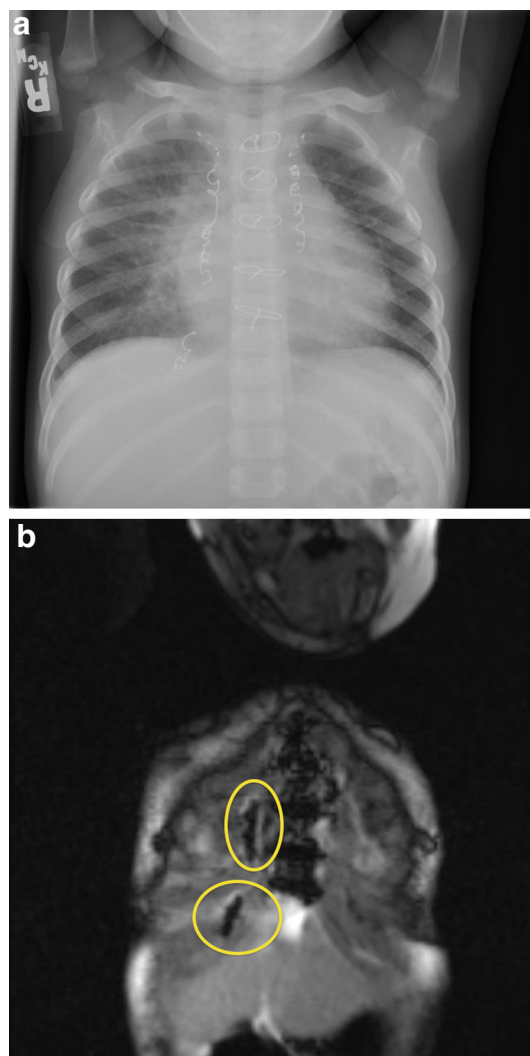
Examples of Inconel coils by chest radiograph and MR image. Typical imaging artifact from Inconel-based embolization coils in a patient with single-ventricle heart disease with coils in both the left and right internal mammary arteries as well as veno-venous collateral vessels. Coil position is shown on a posterior–anterior projection plain film radiograph (a) and on a scout coronal localizer image through the anterior chest wall. The relatively small artifacts are seen immediately to the patient's right of the sternum (*yellow circles*) (b)
